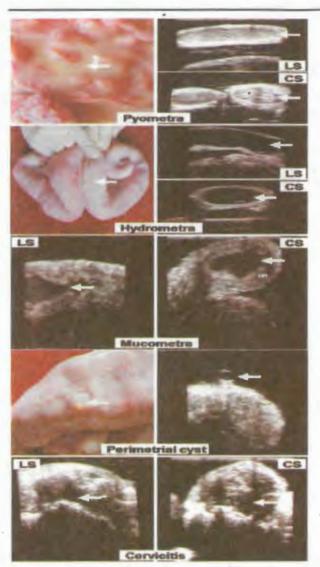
Photographs and sonograms of uterine and cervical abnormalities in buffalo genitalia. LS: Longitudinal section, CS: Cross section
